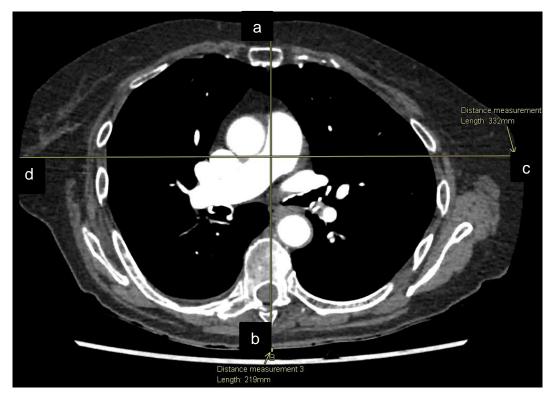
4: Axial CT images visually demonstrating chest depth of 21.9 cm (the line between A and B).
